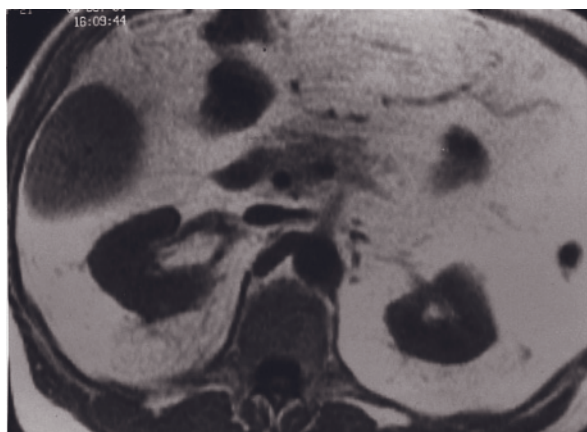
Severe acute bilateral pyelonephritis. Coronal T2-weighted SS-ETSE (a) and transverse T1-weighted precontrast (b) and immediate postgadolinium (c, d) SGE images. The kidneys are enlarged and demonstrate heterogeneous signal intensity on T2- and T1-weighted images and heterogeneous enhancement after administration of gadolinium. Note that the heterogeneous enhancement has a striated nephrogram appearance, which is a feature that may be observed in acute pyelonephritis. Coronal T1-weighted SGE and T2-weighted single-shot echo-train spin-echo images (e, f) demonstrate enlarged right kidney, free fluid adjacent to the inferior pole (arrows, e, f), and stranding in the adjacent fat tissue (arrows, e, f) in another pregnant patient with acute pyelonephritis. Based on precontrast images, acute pyelonephritis can be diagnosed in pregnant patients, and gadolinium chelates should not be used in pregnant patients if their use is not deemed essential.
